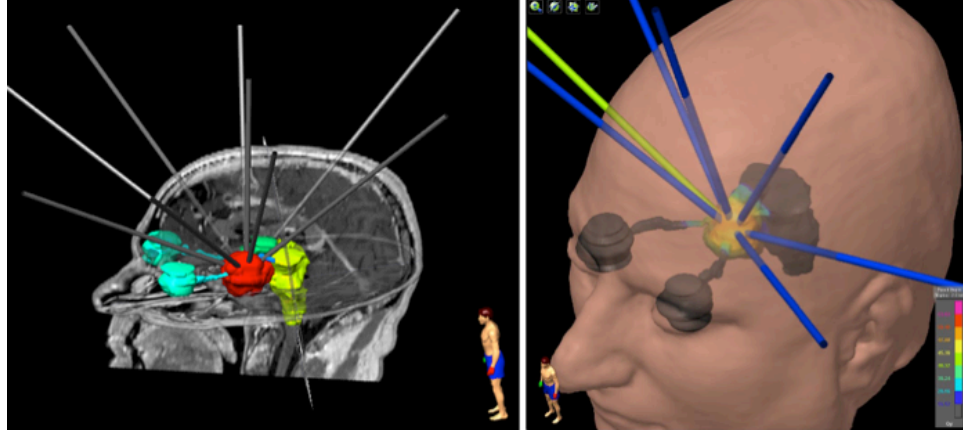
Representation of two different radiation beam configurations on a treatment planning system over a CT scan (left) and in a three-dimensional reconstruction of the head of the same patient (right). [This image is used under permission of the Hospital Universitario Puerta de Hierro Majadahonda, Madrid, Spain].
